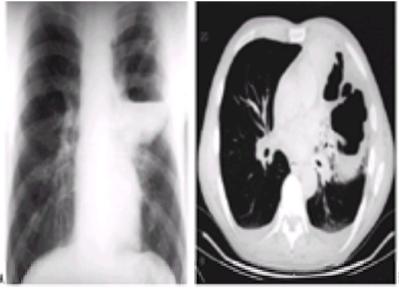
A: Anaerobic lung abscess. On chest x-ray film, a large abscess cavity with an air-fluid level fills nearly the entire left upper lobe. Note that some streaky remnants of lung tissue remain visible, as do several smaller air-fluid levels. An area of pneumonia, seen here in the left infrahilar region, is commonly noted, reflecting infected but not yet necrotic lung adjacent to the abscess. B: On CT, the multilocular nature of the lung abscess is apparent. Small, air-containing structures in a region of perihilar pneumonia represent bronchiectasis and early foci of necrosis. Note the shaggy interior cavity wall, typical of lung abscess.
